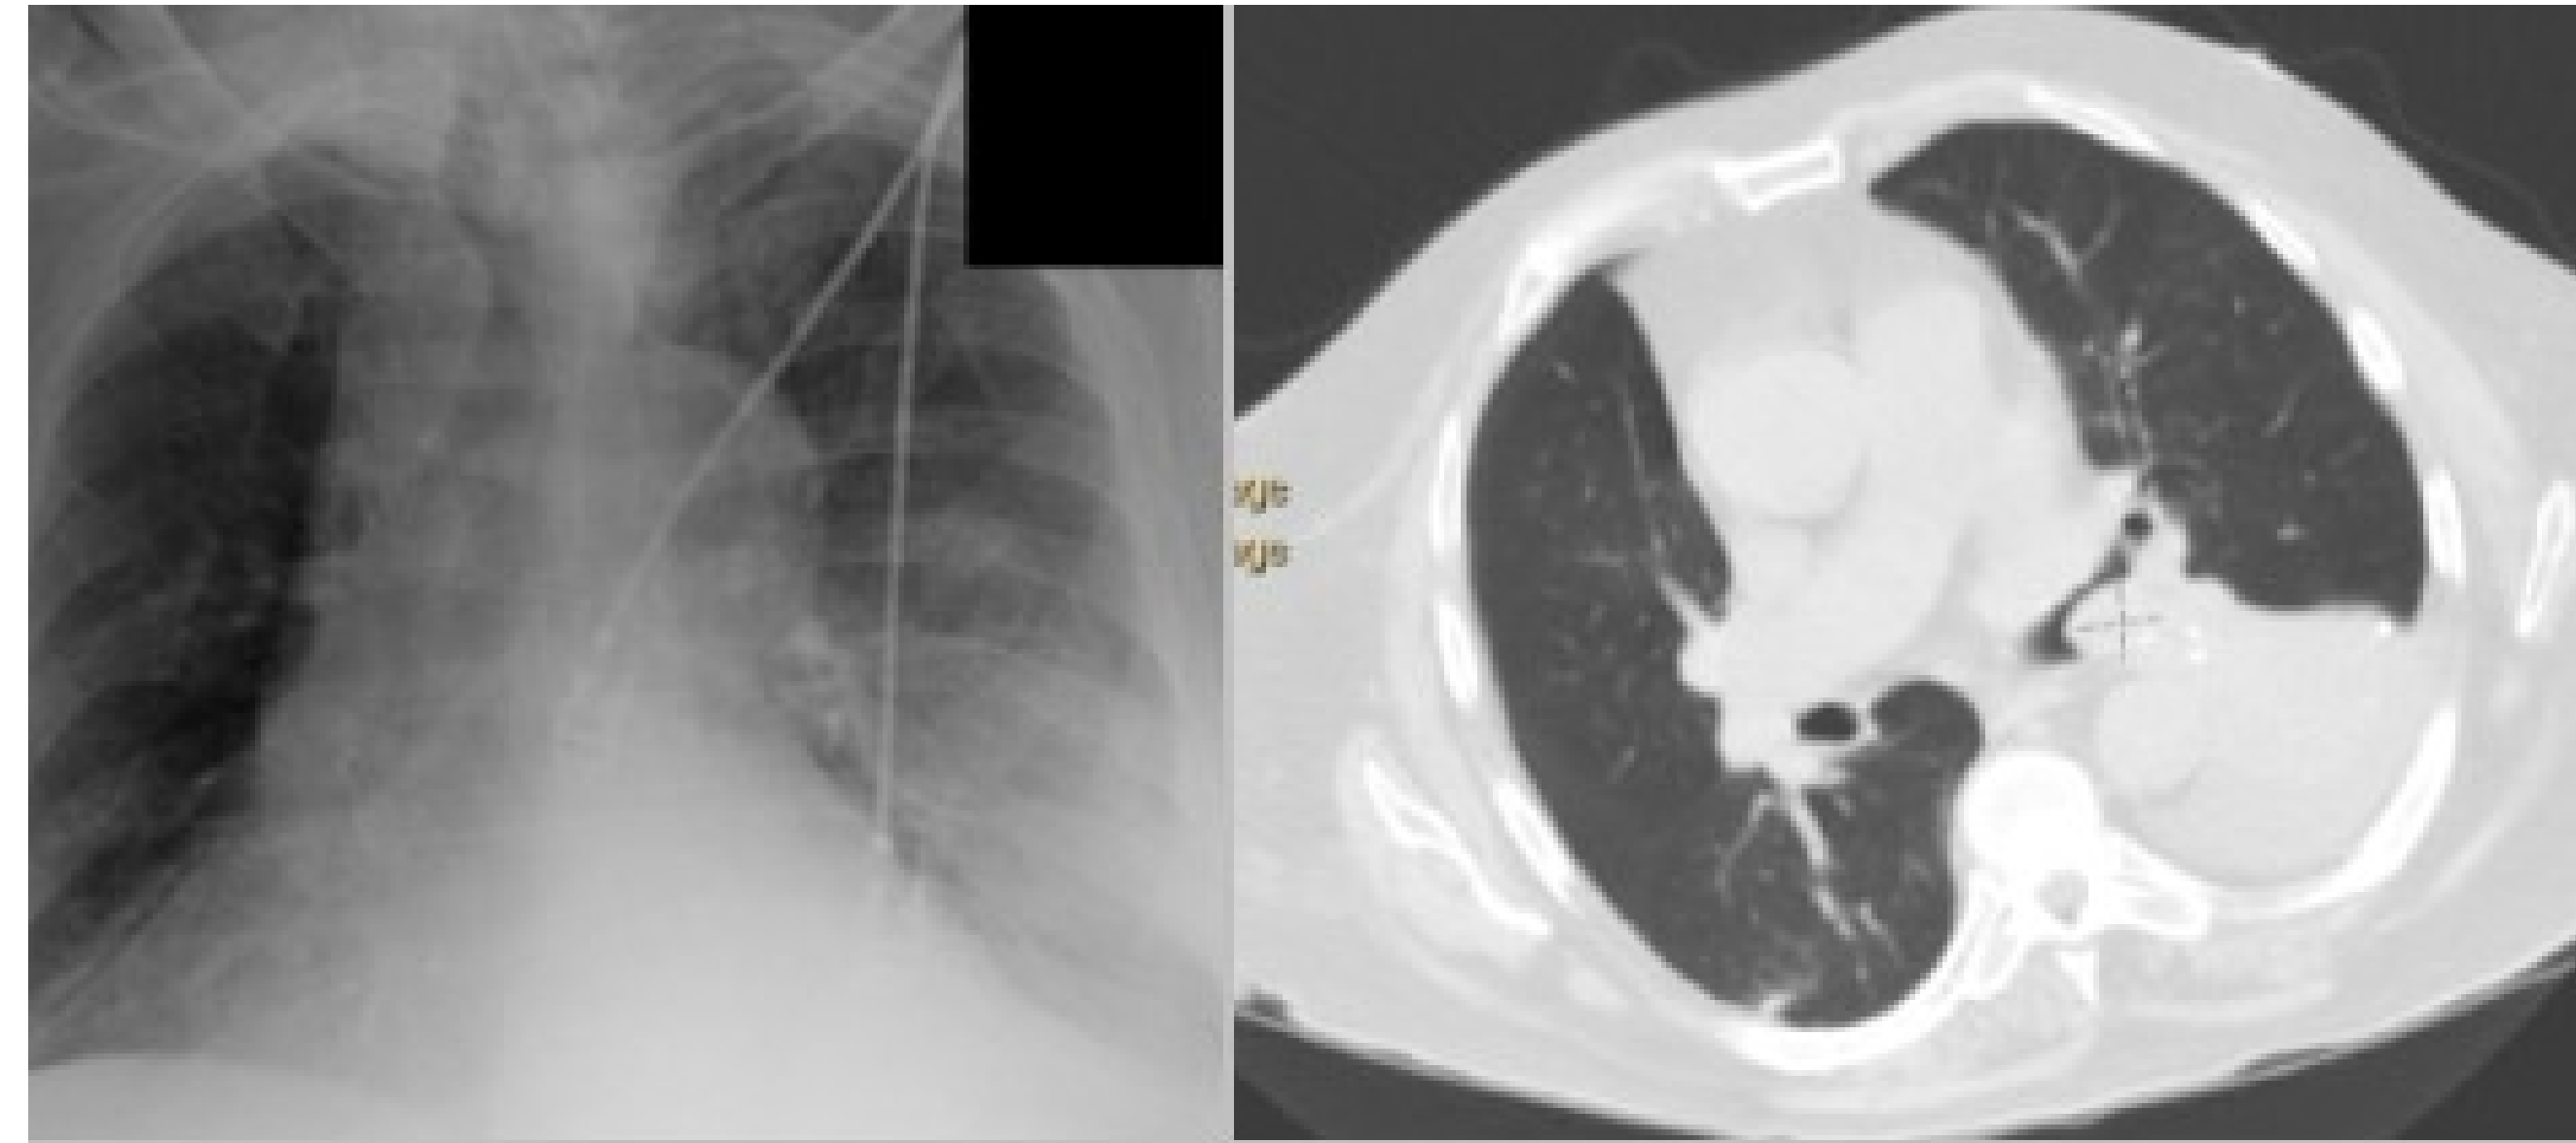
Chest X-ray demonstrating pulmonary consolidation of left lower lung field with signs of possible pleural fluid collection. CT chest revealed left lower lobe post obstructive pneumonia secondary to an endobronchial lesion at the level of the left main bronchus bifurcation
